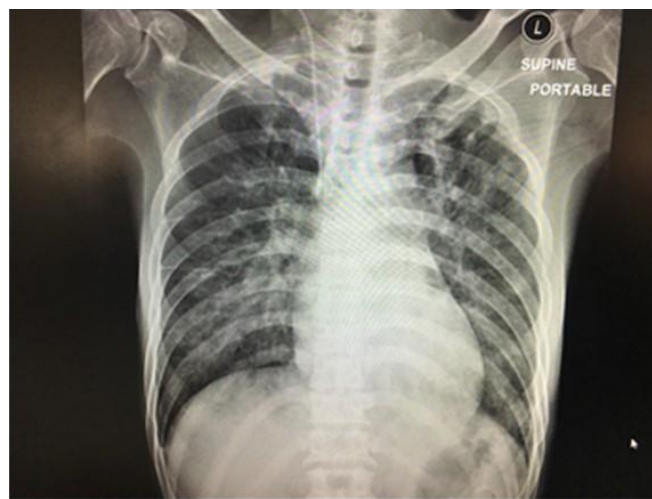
Bilateral patchy infiltration on chest radiography
